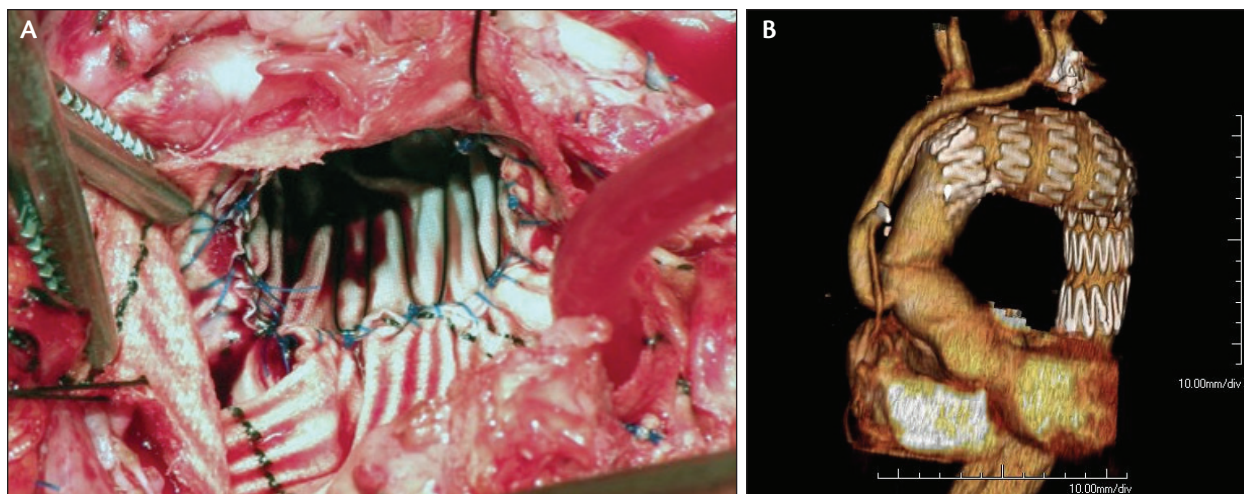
Proximal open thoracic aortic repair after TEVAR using a “reverse frozen elephant trunk” approach. An intraoperative photo (A) showing the stent graft in the arch being sutured to the surgical graft proximally, as well as a postoperative volume-rendered CT reconstruction (B).
